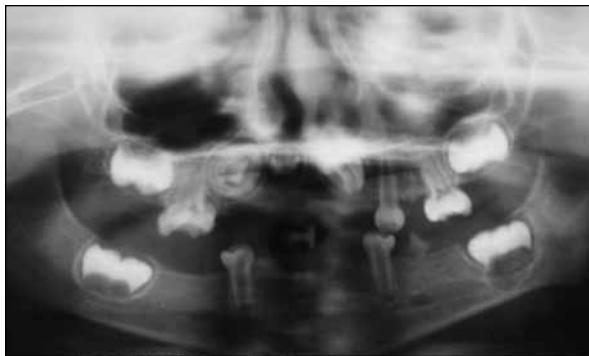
Orthopantomograph at age 2 years, 9 months.
